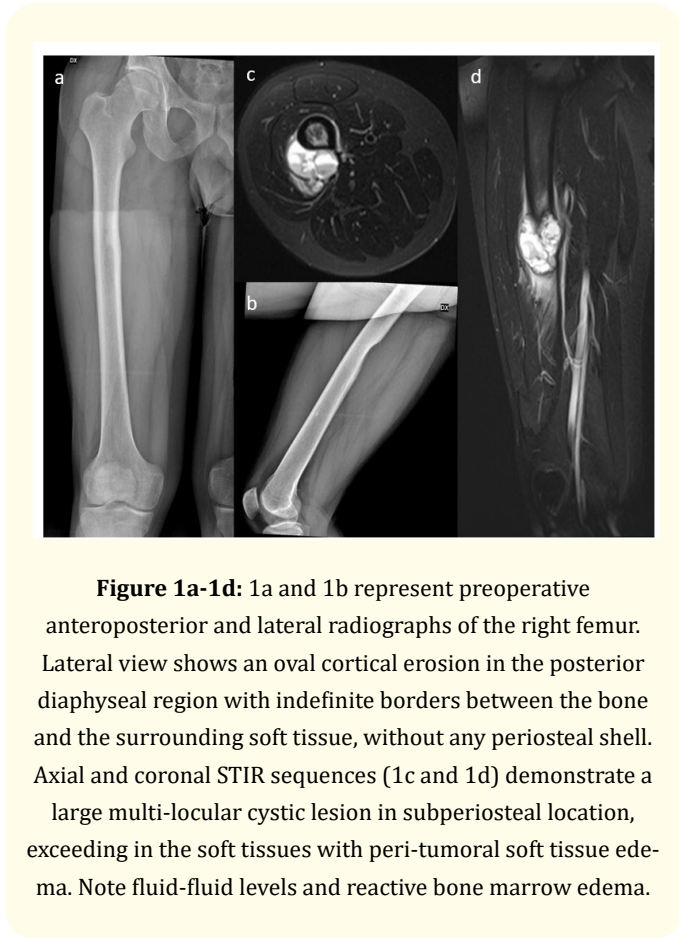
1a and 1b represent preoperative anteroposterior and lateral radiographs of the right femur. Lateral view shows an oval cortical erosion in the posterior diaphyseal region with indefinite borders between the bone and the surrounding soft tissue, without any periosteal shell. Axial and coronal STIR sequences (1c and 1d) demonstrate a large multi-locular cystic lesion in subperiosteal location, exceeding in the soft tissues with peri-tumoral soft tissue edema. Note fluid-fluid levels and reactive bone marrow edema.
